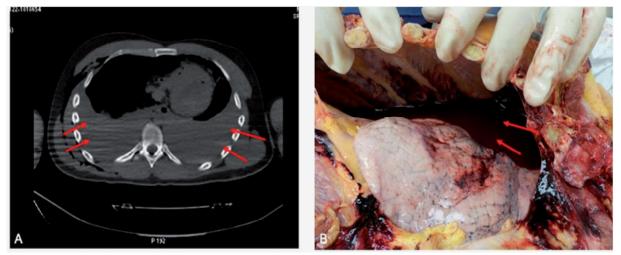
A) Axial computed tomography (CT) scans: bilateral Massive hemothorax (red arrows) with ribs fracture in a case of car accident. B) Autopsy examination. The presence of the bilateral massive hemothorax (red arrows) and ribs fracture the PMCT findings confirmed
